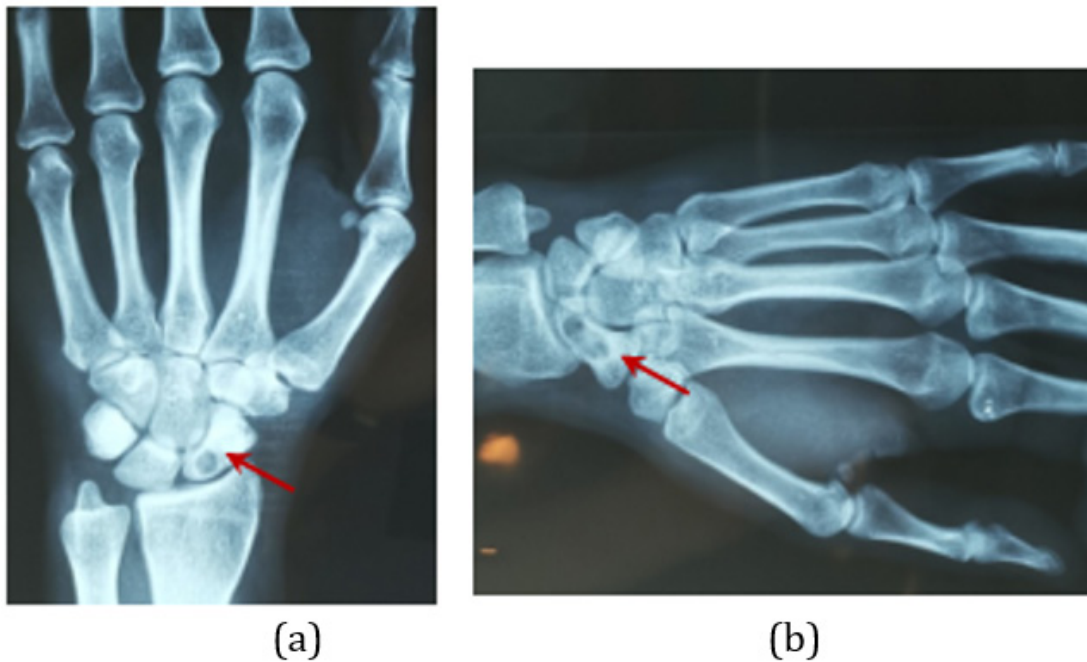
Preoperative x-Rays (AP- oblique) which describe a intraosseous cyst on left scaphoid bone (red arrow).
